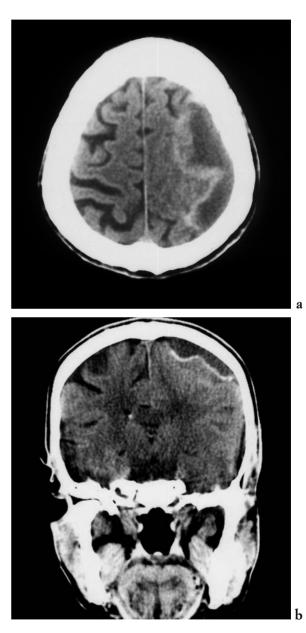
Subdural haematomas. Axial and coronal CT shows small, chronic subdural haematoma over the convexity of the brain is observed which is better seen on coronal scans. [a) axial CT; b) coronal CT].
